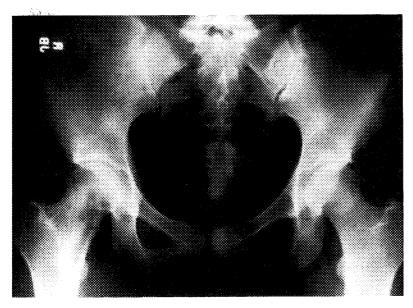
Fibrous dysplasia. An adolescent girl presented with right hip pain. An anteroposterior radiograph of the pelvis shows a lesion in the right femoral neck. The lesion has a "groundglass" appearance and is marginated by mature reactive bone, which is especially pronounced distally. There is a nondisplaced femoral neck pathologic fracture.
